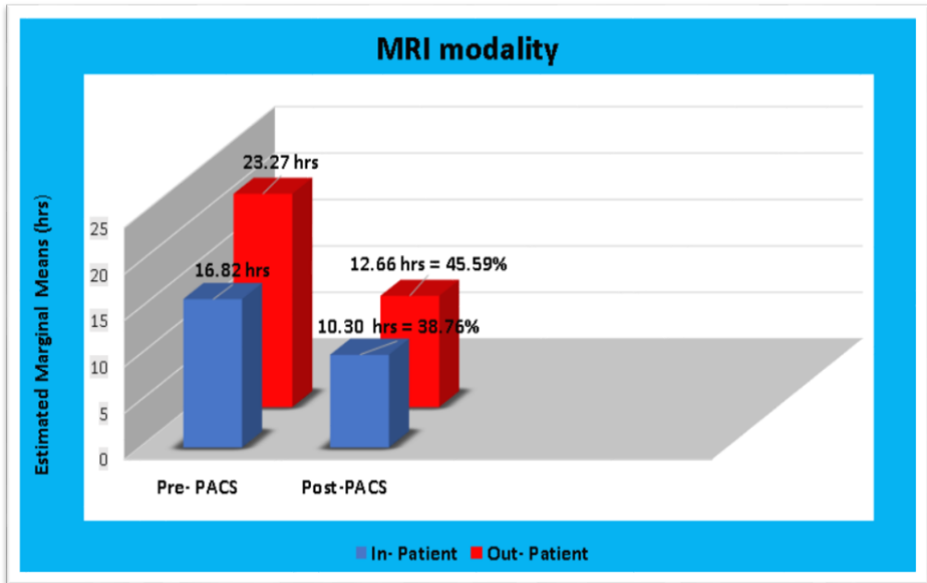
Estimated marginal means (hours & percentage) of report TAT for the MRI modality
